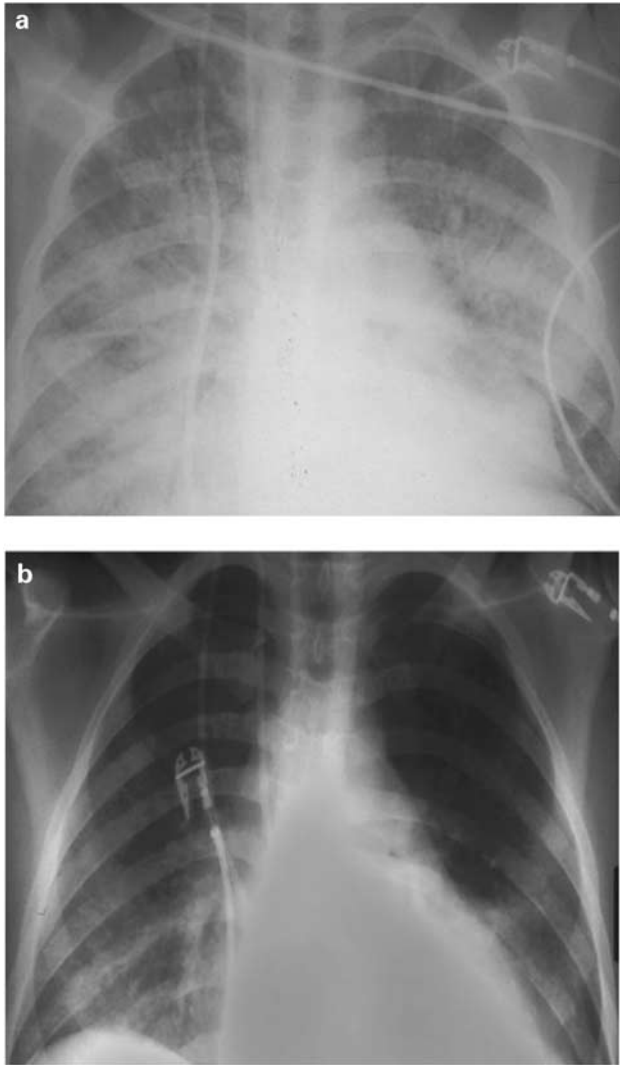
Chest radiographs obtained on day 0 (Figure 3a) and day 4 (Figure 3b) of therapy with etanercept for a 14-year-old patient who developed IPS 8 days following a 4/6 matched PBSCT for recurrent renal carcinoma.
